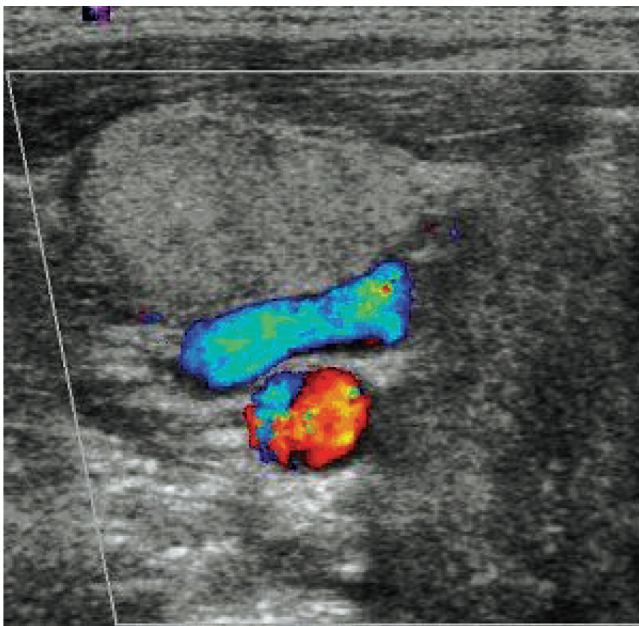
Case 2: Transverse color Doppler image: submandibular mass at the right anterior cervical triangle. The mass appears as a solid lesion with homogeneous internal structure without vascularity.
